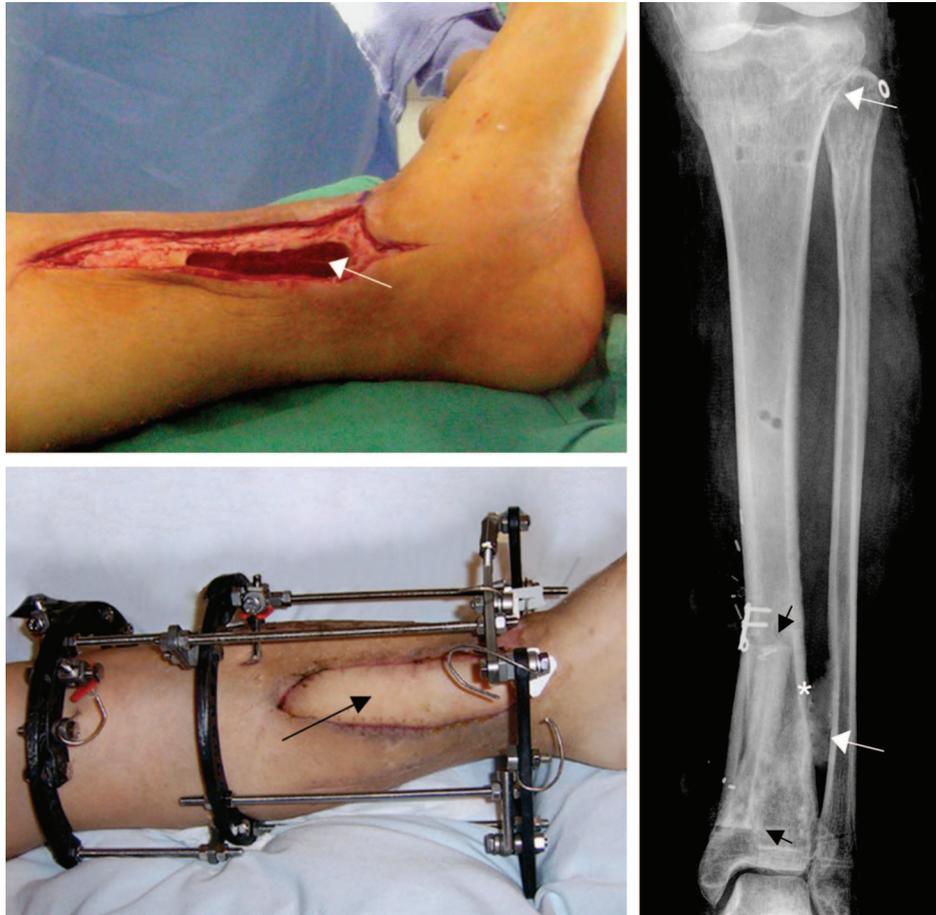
(Above, left) At the initial debridement, the extent of a distal unroofing and careful preservation of the periosteal blood supply is evident. (Below, left) Three days later, the patient underwent reconstruction with an external fixator, a vascularized fibula with skin paddle (black arrow), and autogenous cancellous grafts. (Right) An anteroposterior radiograph at the time of external frame removal shows the healed fibular graft (black arrow), healing of the original fracture (*), and union of an ipsilateral fibular synostosis (white arrows) performed during her initial hospitalization.
